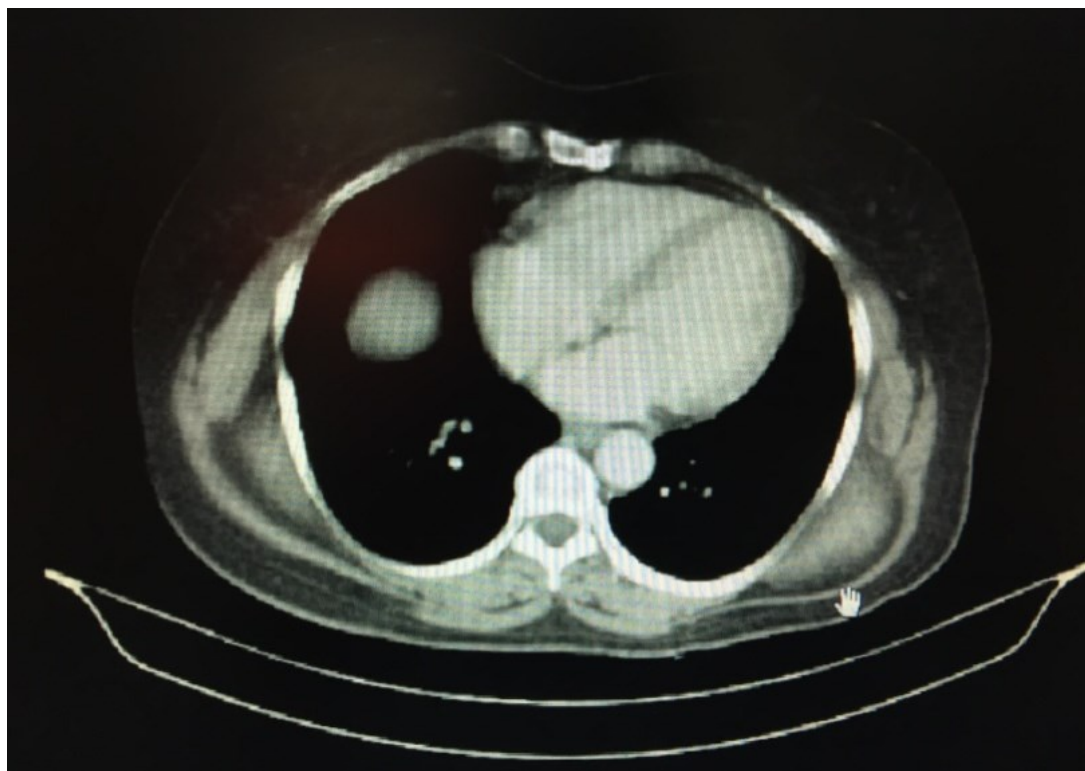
Thoracal CT image shows left infrascapular, well circumscribed mass, reaching chest wall.
